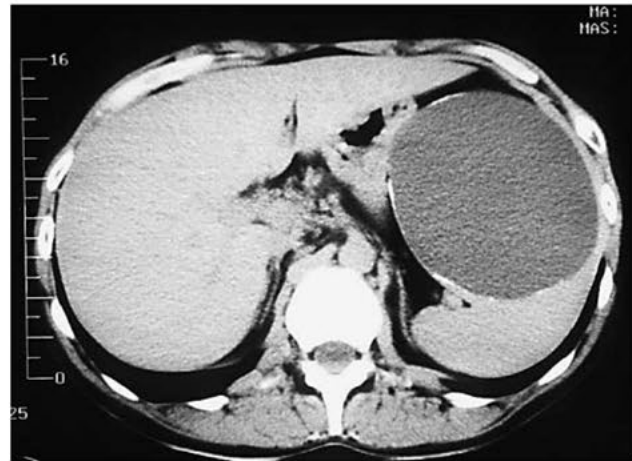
Abdominal CT scan showing an 11-cm anterior splenic pseudocyst. Successful laparoscopic cyst wall unroofing.
